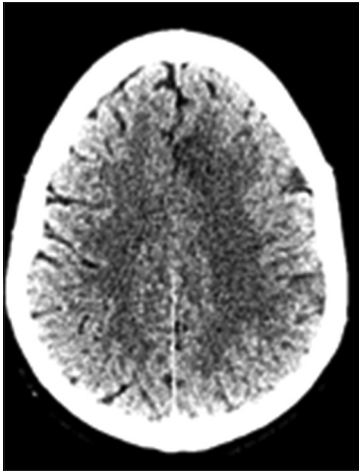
Follow-up CT Brain – no evidence of any fresh infarcts post-procedure
